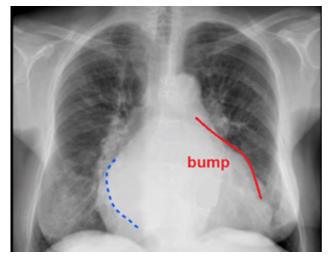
Chest X-ray of the thorax. PA view. Left atrial dilation leads to a bumping or convex image of the gulf of the heart.
